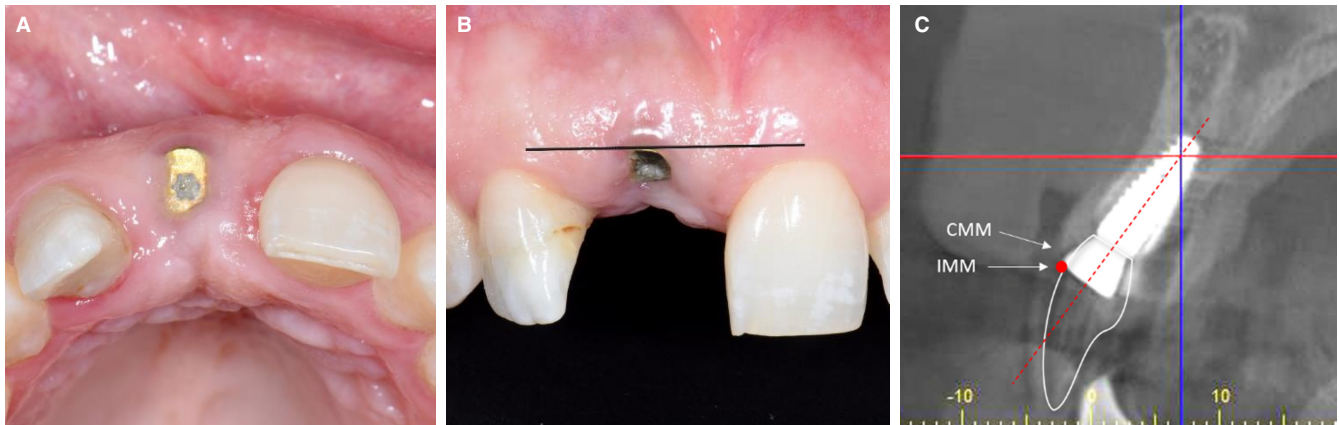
A, The implant in the maxillary right central incisor has been placed in a facial malposition. The facial aspect of the healing abutment is at the limit of the curvature of the arch at the level of the gingival margin. B, From the facial aspect, the mucosal margin at the implant is approximately 1.5 mm apical to that of the contralateral central incisor. C, The corresponding sagittal view of the CBCT scan clearly demonstrates the facial and axial malposition of the implant. The central axis of the implant in (red dotted line) shows the implant emerging facial to the incisal edge of the anticipated restoration (white outline of the crown). The red dot marks the IMM located 1.5 mm coronal to the CMM. The clinician then has to determine whether a crown, abutment, and minimum 1 mm soft tissue thickness can be accommodated at the level of the red dot without extending facially to it. In this case, it was determined that the facial and axial malposition was too severe, and the decision was therefore made to remove and replace the implant. CBCT, cone beam computed tomography; CMM, current mucosal margin; IMM, ideal midfacial mucosal margin
